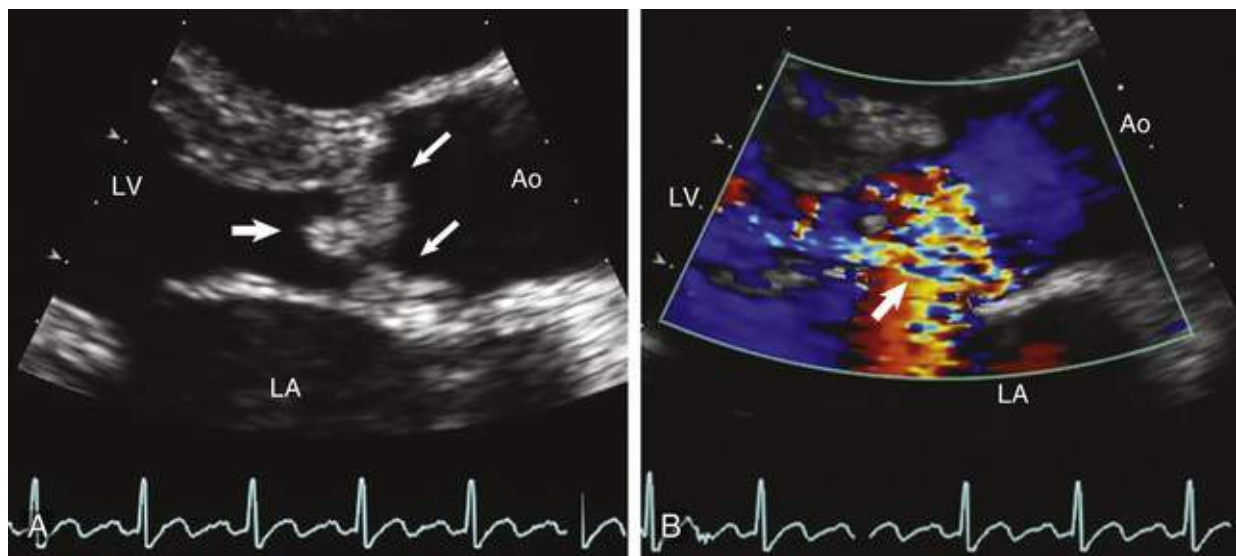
Infective endocarditis of the native aortic valve. A, Transthoracic echocardiography shows vegetations (*small arrows*) attached to the left ventricular aspects of the valve cusps and prolapsing into the left ventricular outflow tract (*large arrow*) during diastole. B, Severe aortic regurgitation (*arrow*) is shown by color Doppler. Ao, Ascending aorta; LA, left atrium; LV, left ventricle.
